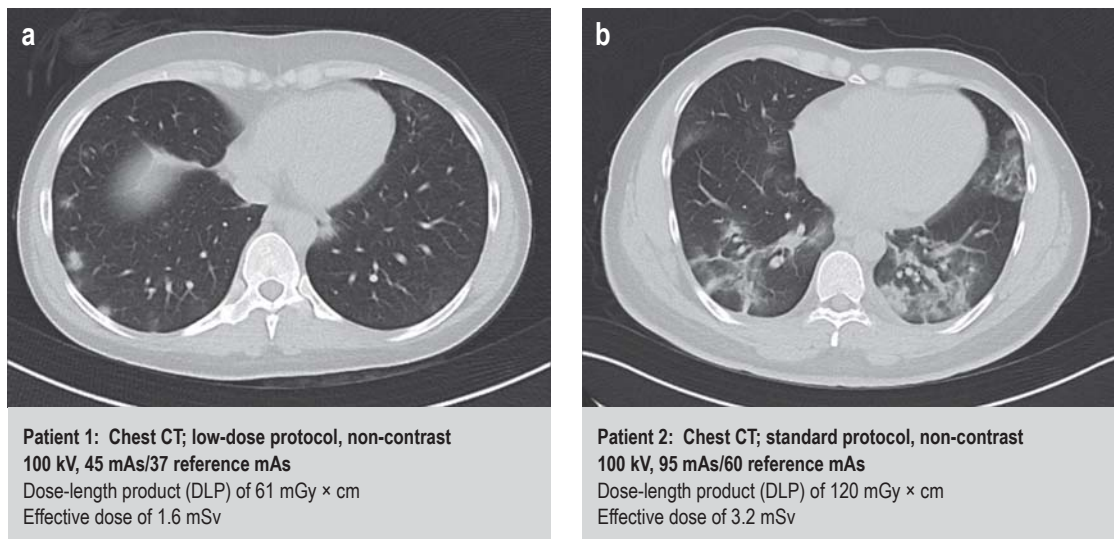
Two axial images of a non-contrast chest computed tomography (CT) scan to rule out inflammatory infiltrates using a low-dose protocol (a) and a standard dose protocol (b) with twice the dose. The effective dose was calculated using the conversion factor of Shrimpton et al. (2016) (23). Despite the differences in image quality and radiation dose, the diagnostic significance remains the same for the two CT studies, as both allow detection of atypical inflammatory infiltrates in the lower lobes.
